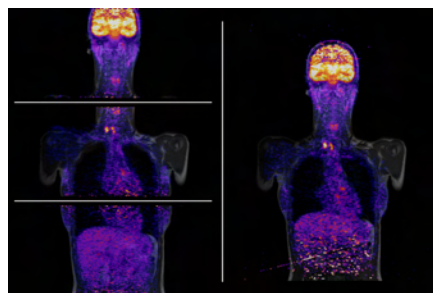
Fused MRI (coronal T1 TSE) and PET datasets of a clinical patient. PET was acquired with MS mode (left) and with CTM (right).
